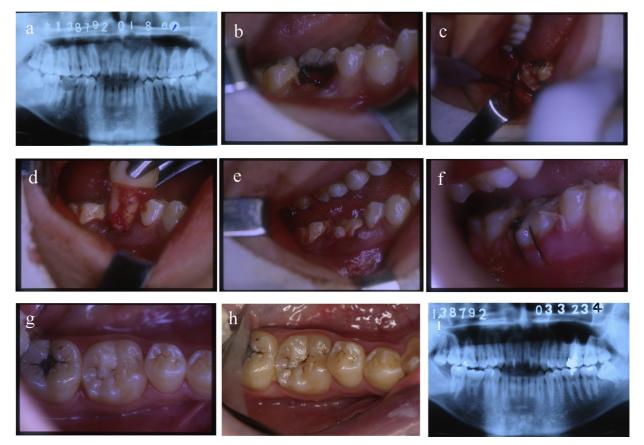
Autotransplantation of a mature third molar tooth in a fresh extraction socket: (a) initial panoramic radiograph; (b) carious lesion in the mandibular right first molar (recipient site); (c) view of the mandibular right third molar in the alveolus (donor site); (d) transplantation of the donor tooth in the prepared receptor alveolus; (e) placement of the donor tooth in the recipient area; (f) suturing and fixation of the transplanted tooth; (g) postoperative view at 2 weeks after surgery; (h) postoperative view at 3 months after surgery; (i) final radiograph obtained 3 months after surgery.
